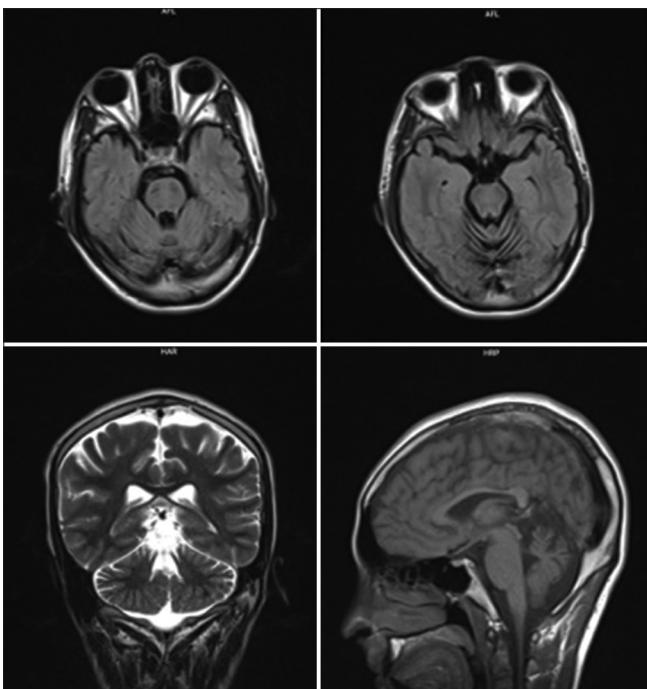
The proband’s brain MRI revealed mild atrophy of superior cerebellar vermis, upper pons, and bilateral linear hypointensities in the pons on T2-weighted sequence.
